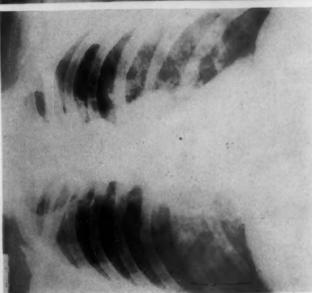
Case 2. Roentgenogram taken October 29, 1957, showing diffuse involvement of both lungs.
